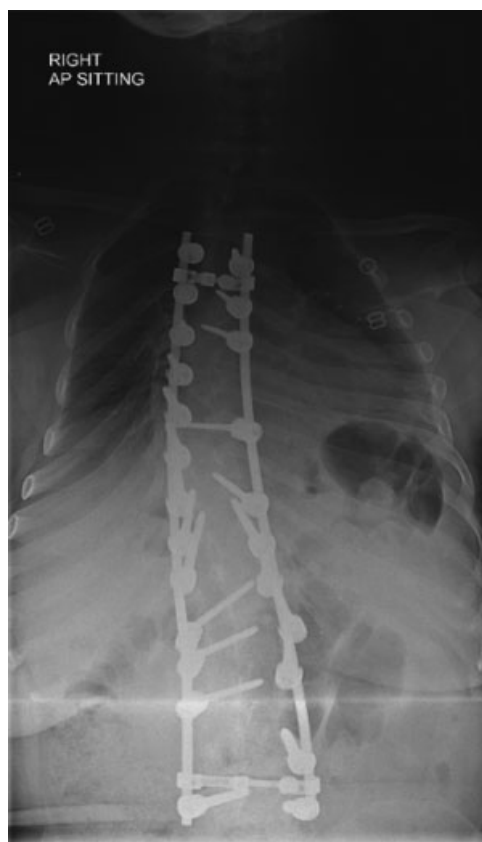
Anteroposterior radiograph: postoperative.
